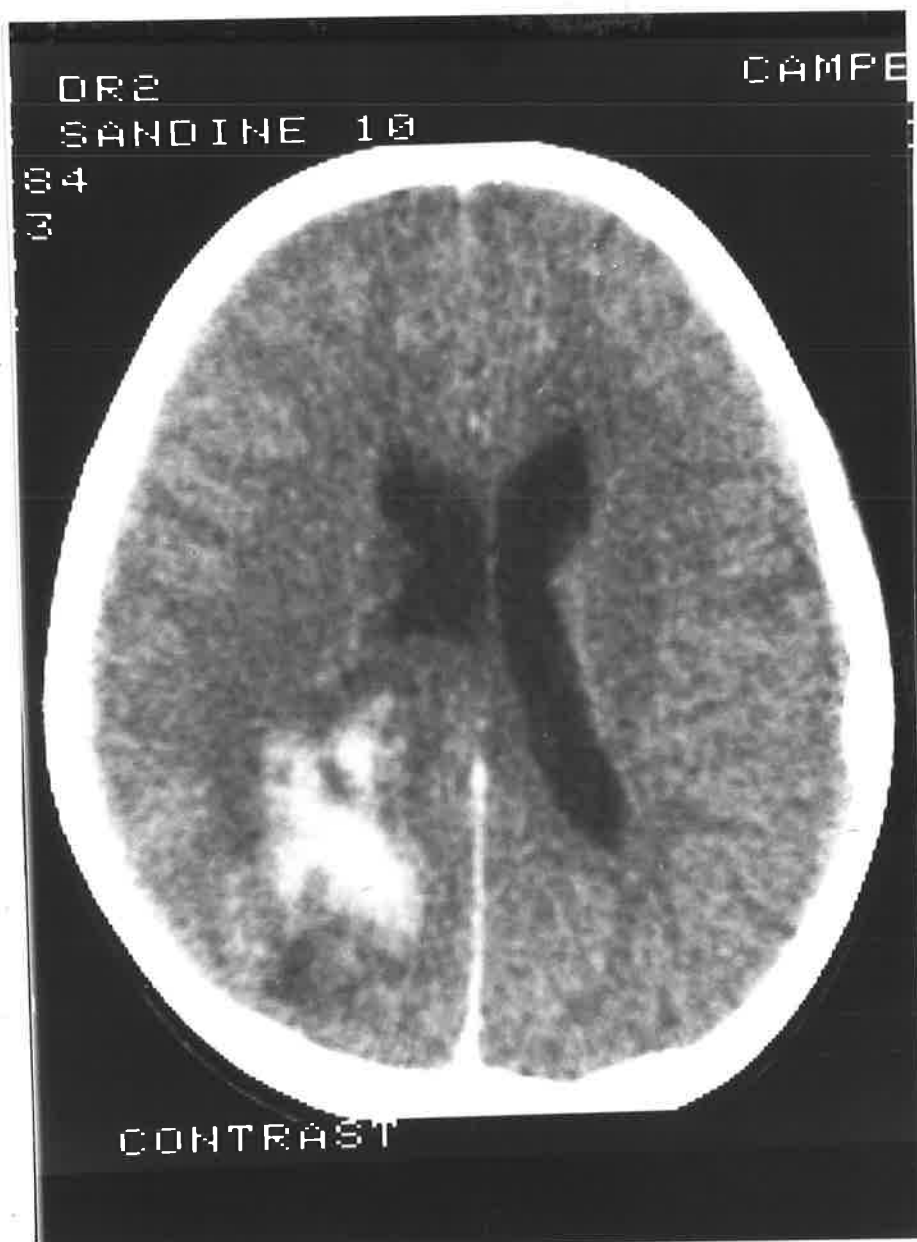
Axial CT scan of the brain of a 10 year old girl who presented with sudden onset of severe headache and left lower limb paresis (Case 2). Angiography confirmed that the right posterior parietal hematoma was due to a ruptured arteriovenous malformation.
